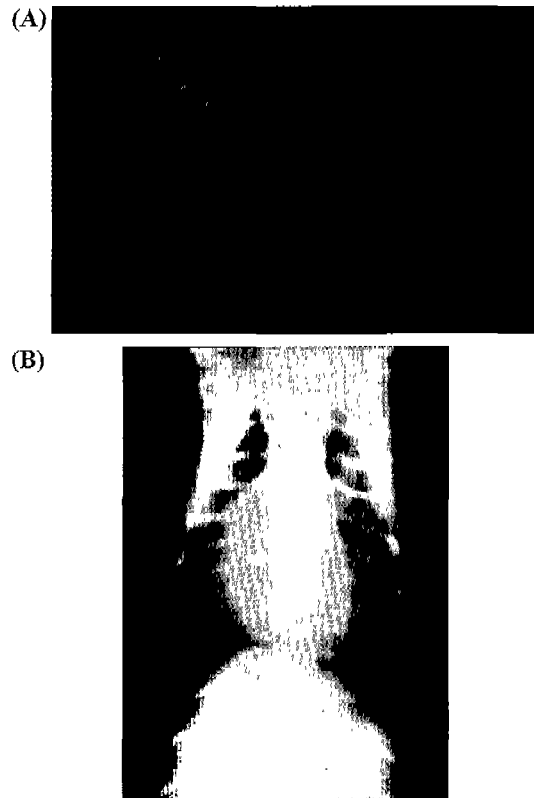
Thoracic radiography, lateral view (A) and ventro-dorsal view (B) on day 1. Air bronchogram due to severe alveolar infiltrate at perihilar region and right lung field and interlobar fissure between right cranial and middle lung lobe were observed.
